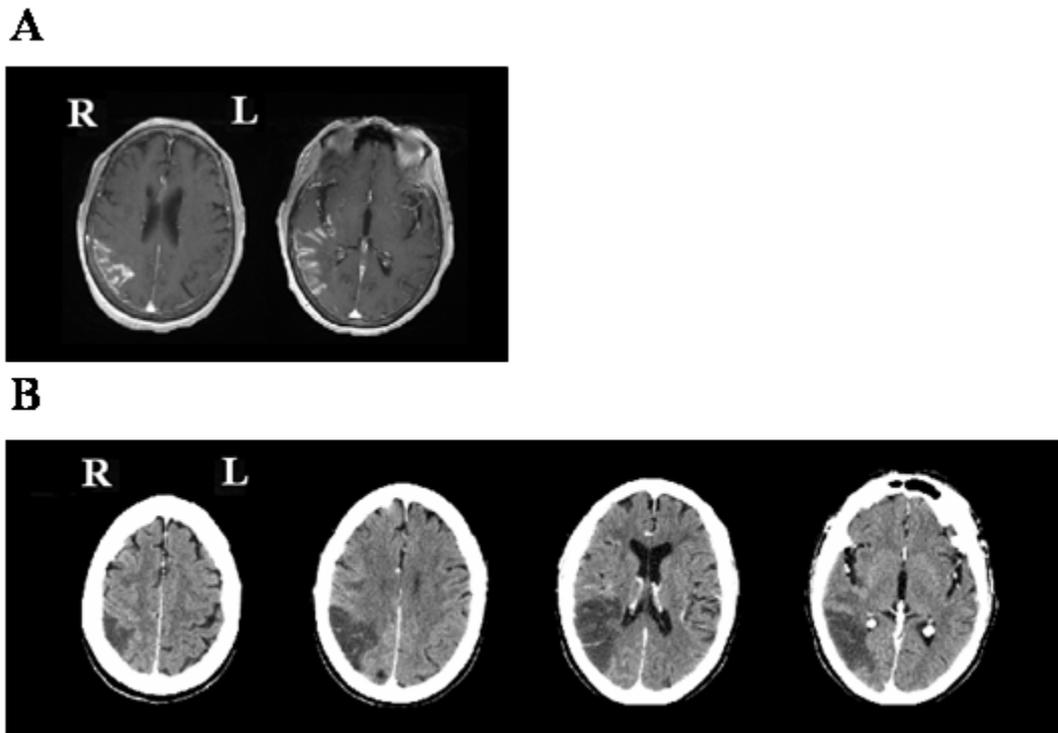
Structural imagery of patient JM’s brain showing a parietal and temporal posterior right cerebral vascular infarction. (A) MRI. (B) CT-scan.
